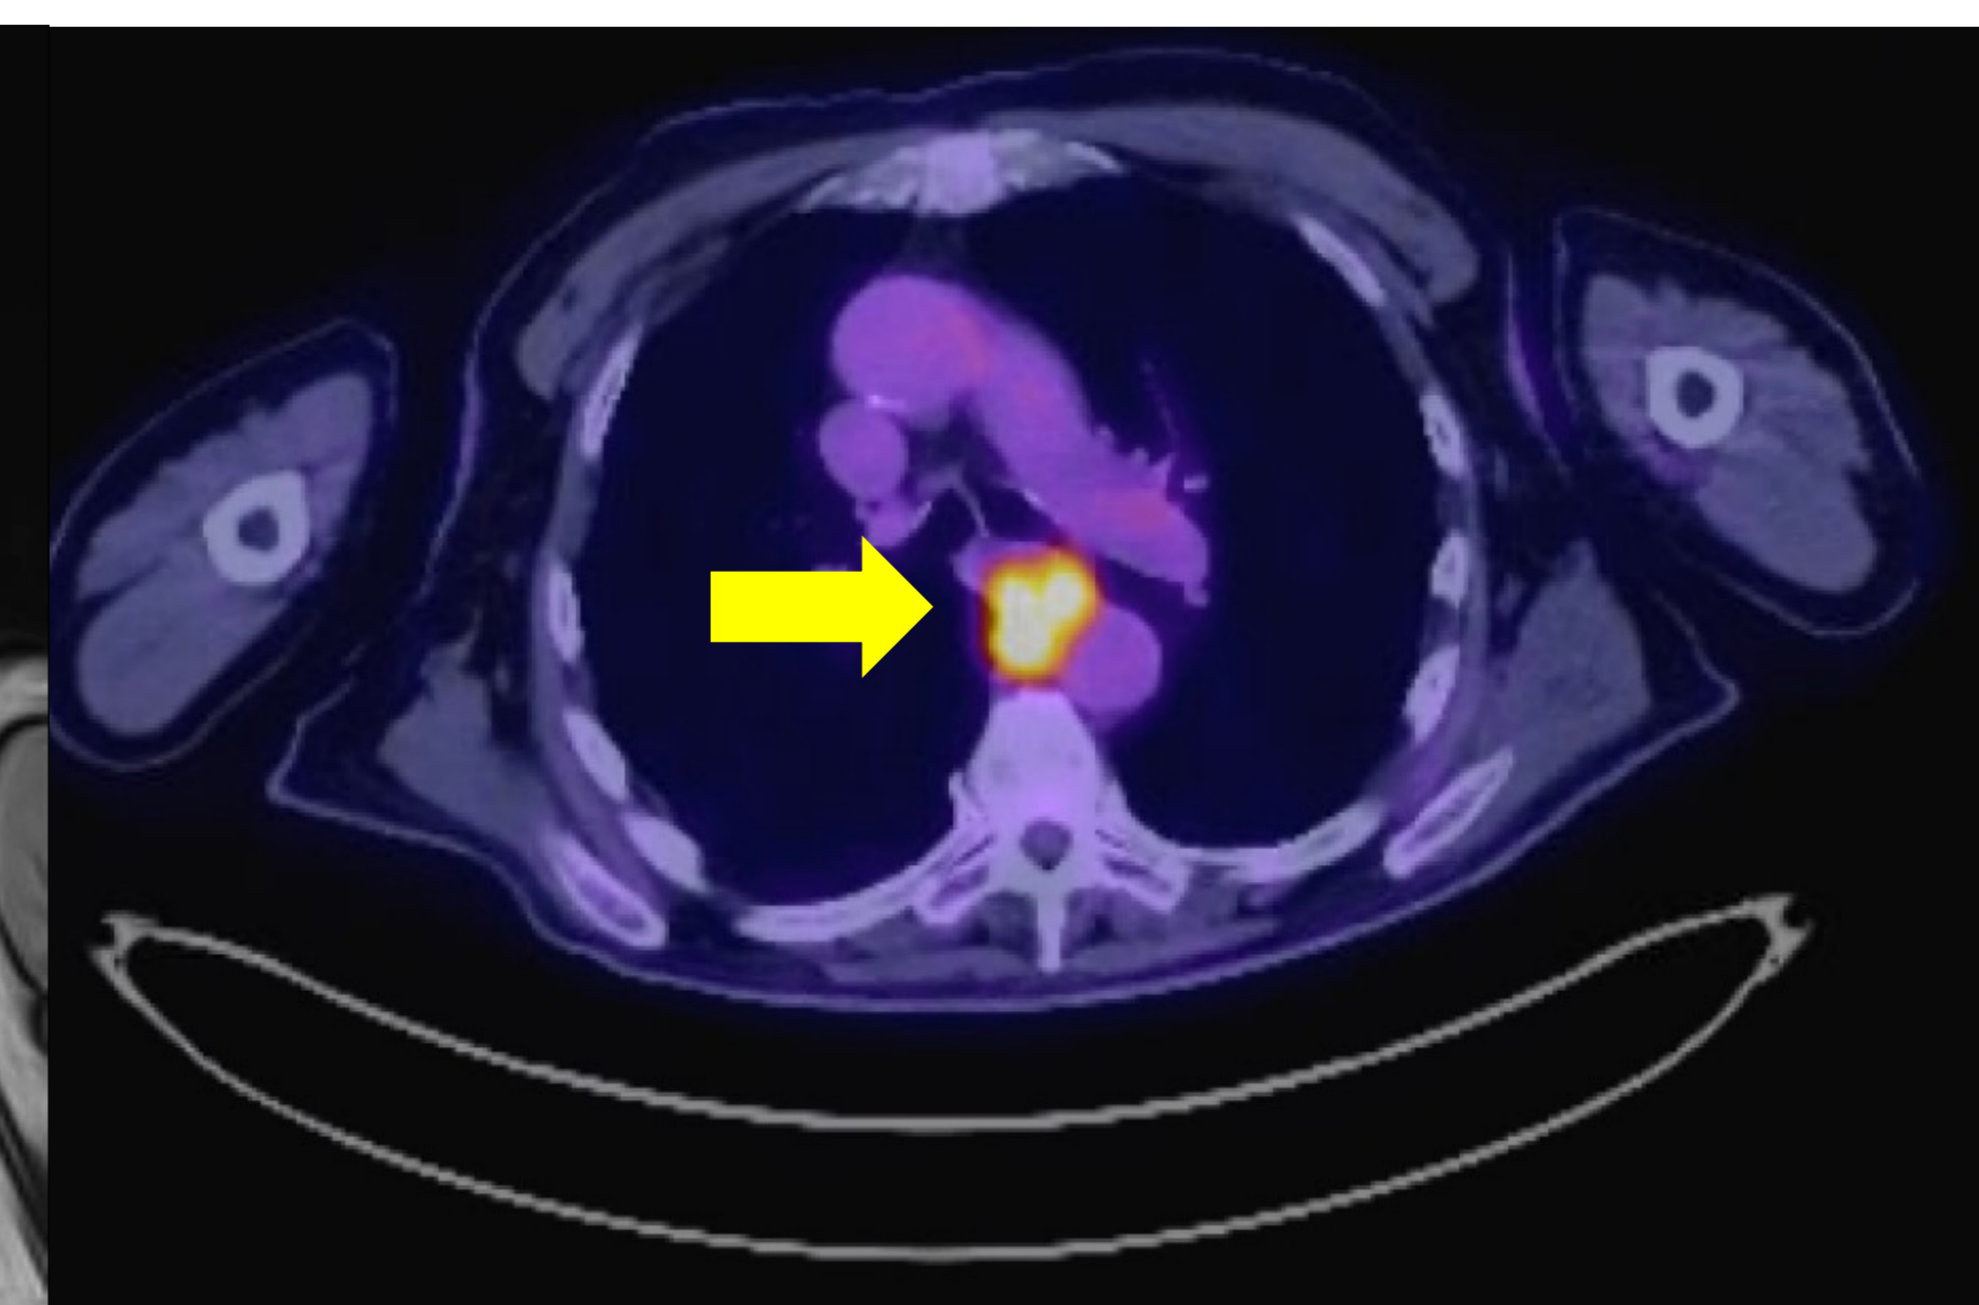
PET CT scan notable for avidity in the posterior peri-esophageal mass.
